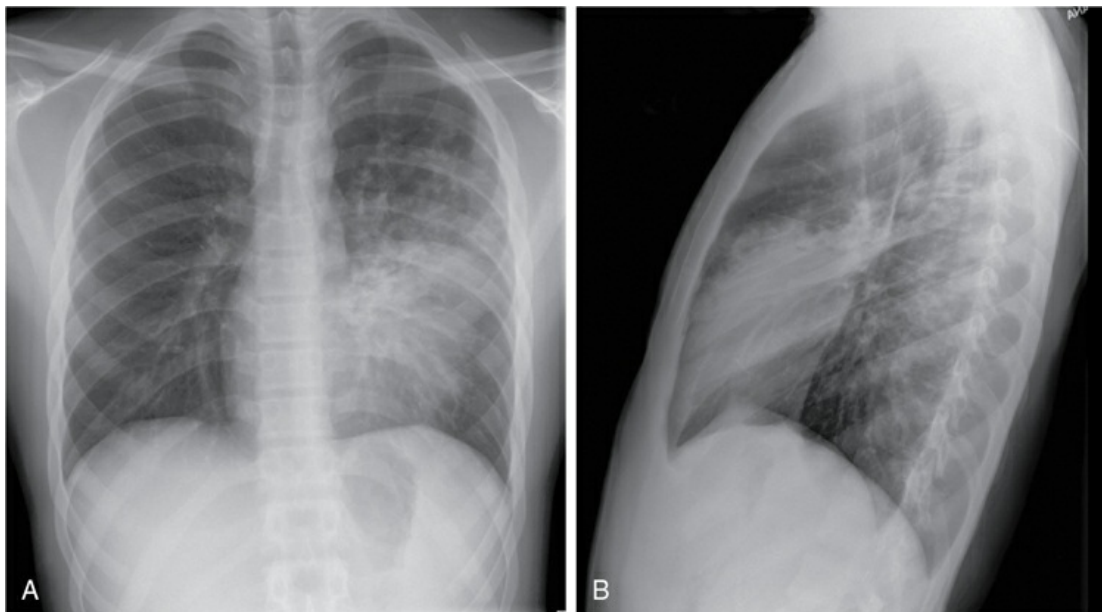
Posteroanterior (A) and lateral (B) chest radiographs show a patchy lobar pneumonia in the lingular segments of the left upper lobe due to *Staphylococcus aureus*. In (A), the consolidation in the lingula is adjacent to the heart and has caused loss of the left heart border (another example of a silhouette sign, as also shown in Fig. 24.1). *Source:* (Courtesy of Dr. Laura Avery.)
